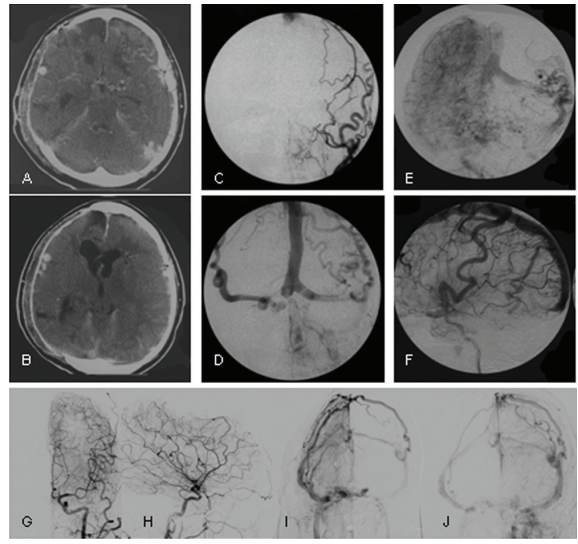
A 18 year old woman had traumatic subdural hematoma at right frontal lobe 6 years ago S/P craniectomy and VP shunt, status bed ridden, had developed recurrent epilepsy and neurological decline for a year. (A, B) CT revealed abnormal dilated leptomeningeal vessels, bilaterally. (C-F) The angiogram revealed dAVF at left sigmoid sinus with bilateral sigmoid sinus thrombosis and severe cortical refluxes (C and D, frontal views of left internal maxillary artery [IMA] on arterial and venous phases; E, frontal view of right internal carotid artery [ICA]; F, lateral view of left ICA). (G-J) Angiogram of post successful eradication of the shunt by combination of transarterial glue embolization and surgery showing regression of the venous congestion with reopening of both sigmoid sinuses (G and H, frontal and lateral views of left common carotid artery; I and J, frontal views on venous phase of right and left ICAs). However, patient had slightly clinical improvement.
